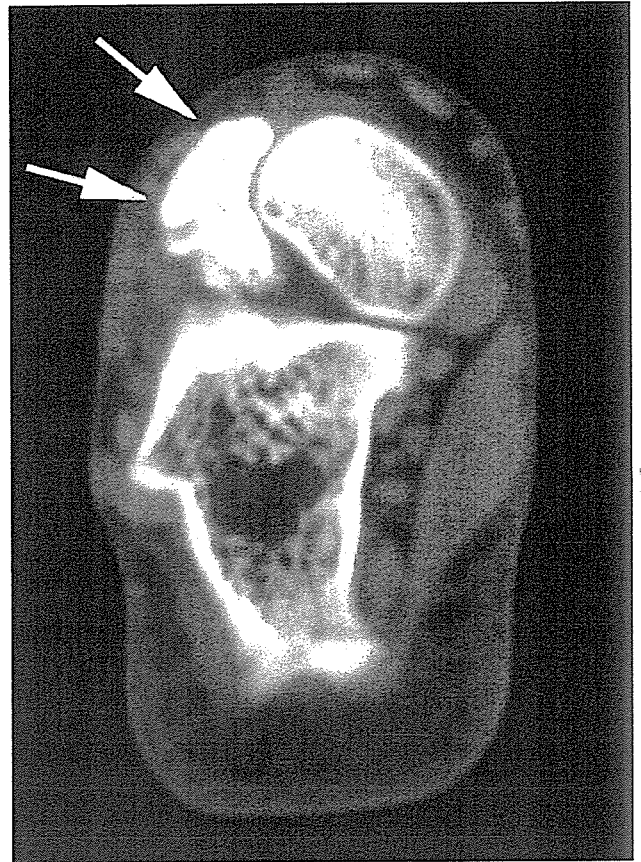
Unenhanced CT image obtained in a 14-year-old boy with synovial sarcoma (low-grade) of left foot. Image obtained at the level of talus head shows a dense calcification (arrows).
